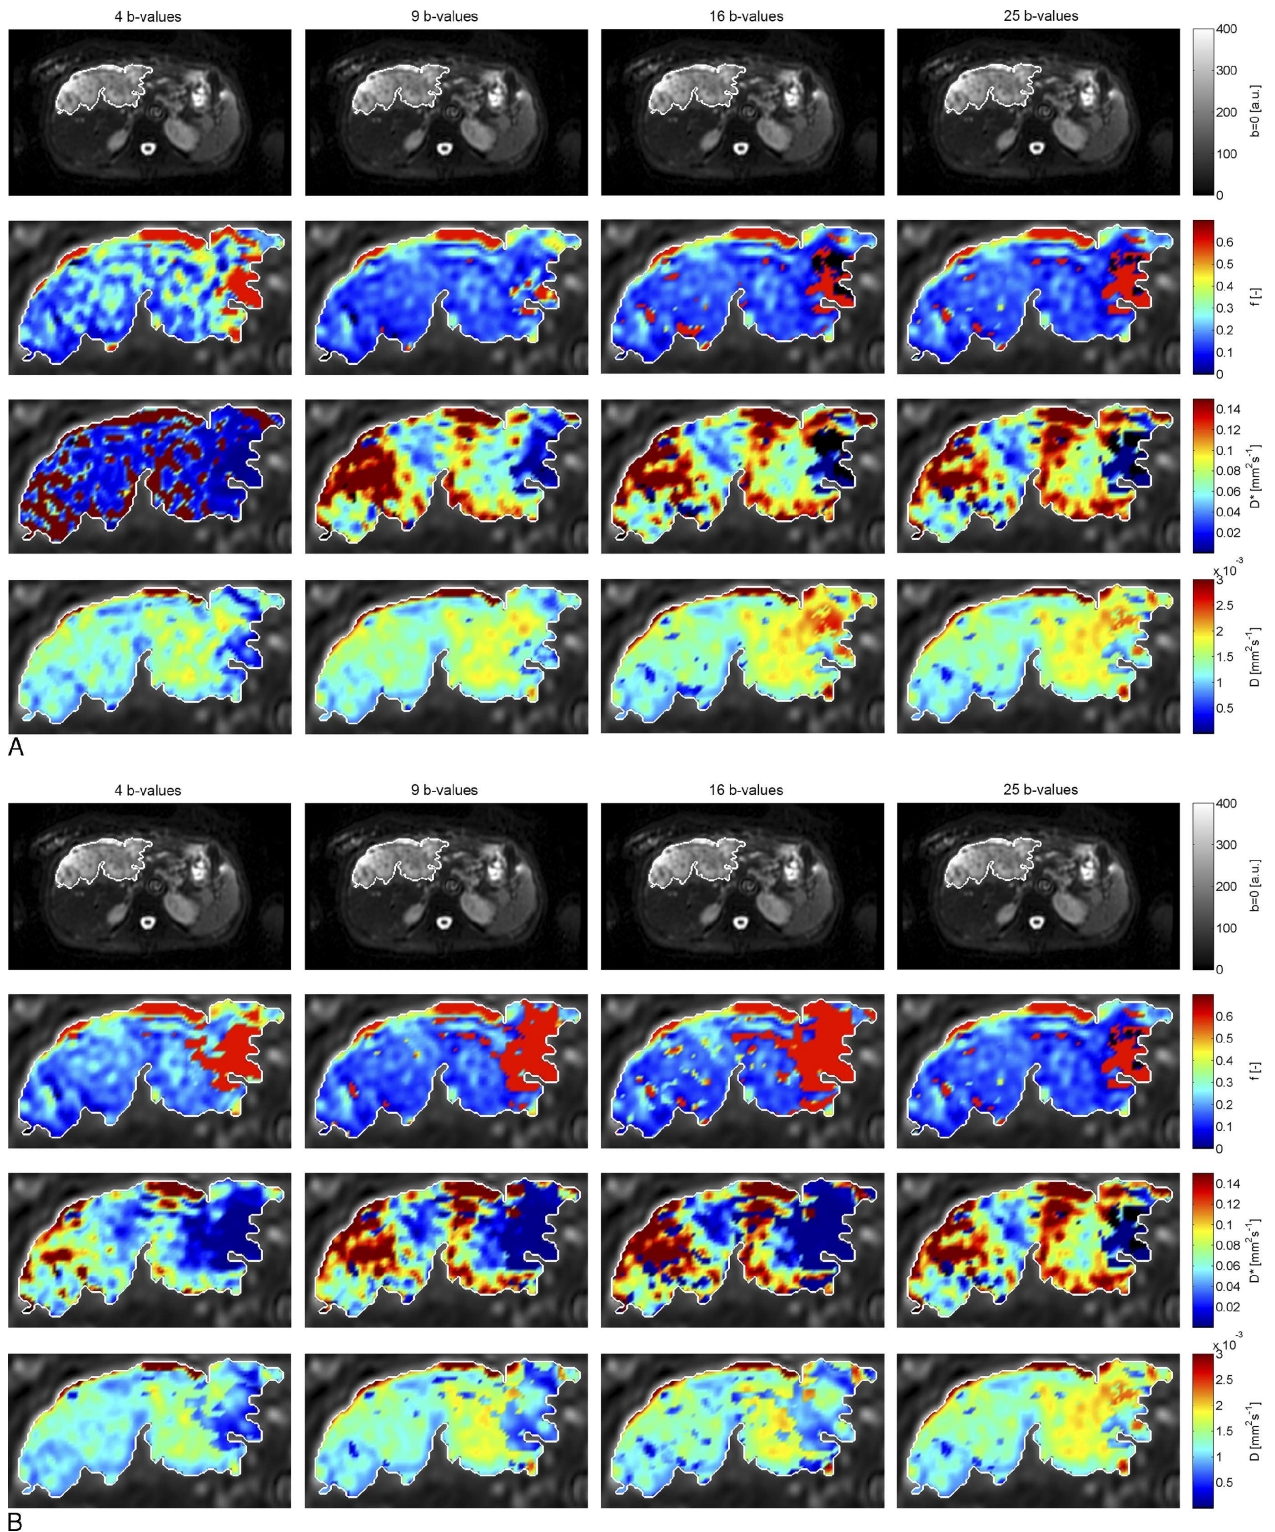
Example of IVIM parameter maps calculated with (A) 4– (far left column; Döpfert et al¹⁷), 9– (left column; Cohen et al¹⁰), 16– (right column; Wurnig et al¹⁷), and 25– (far right column; reference) b -value distributions; (B) optimal 4– (far left column), 9– (left column), 16– (right column), and 25– (far right column) b -value distributions. The top row shows an axial unweighted ($b = 0$ s/mm²) DWI image with a liver lesion. The liver lesion ROI is indicated by a white line in all images. The second row shows the perfusion fraction (f) maps, the third row shows the pseudodiffusion (D^*) maps, and the bottom row shows the diffusion (D) maps. The map images only show the area containing the liver lesion ROI. The maps clearly show differences when calculations are performed with less b -values, and they also show that the tissue inside the ROI is inhomogeneous. The optimal 4– and 9– b -value distributions perform better than the corresponding literature distributions. However, in this liver lesion, the 16– b -value distribution by Wurnig et al performs better than the optimal 16– b -value distribution. Figure 1 can be viewed online in color at www.investigativeradiology.com.
